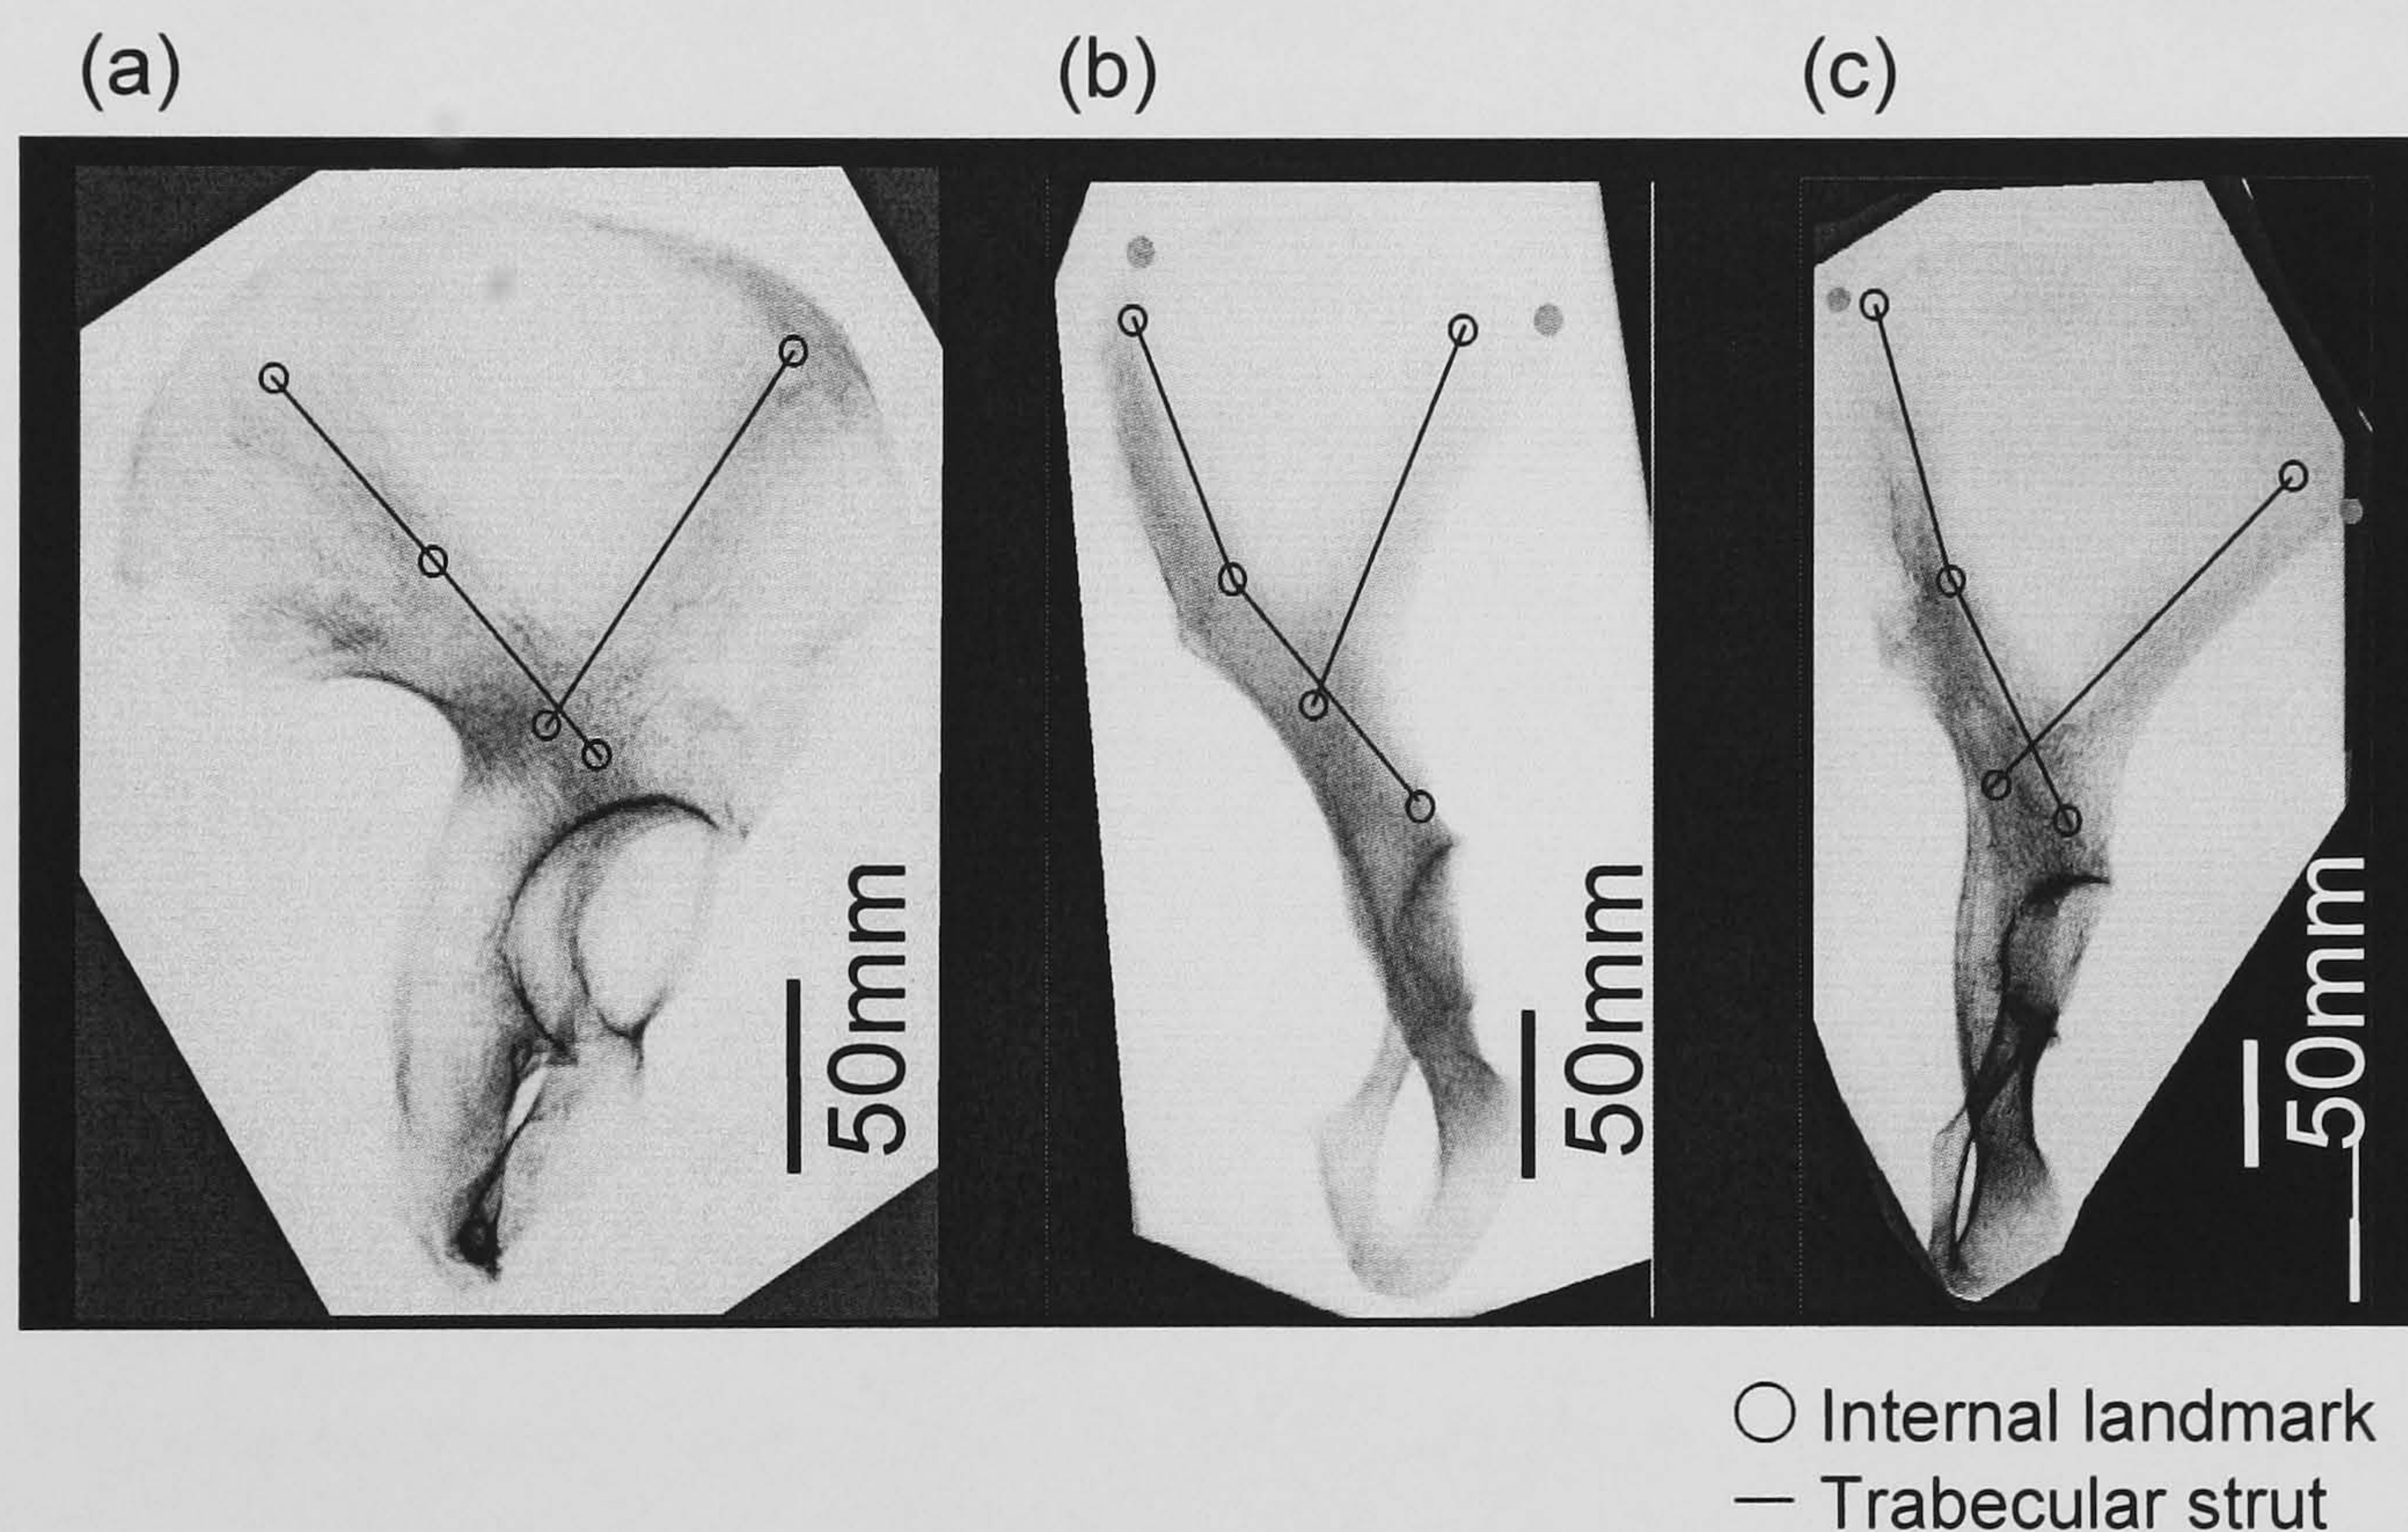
Digitised internal (trabecular) landmarks. Pelvic radiographs (a) *H. sapiens*. (b) *P. t. troglodytes* and (c) *G. g. gorilla*.
